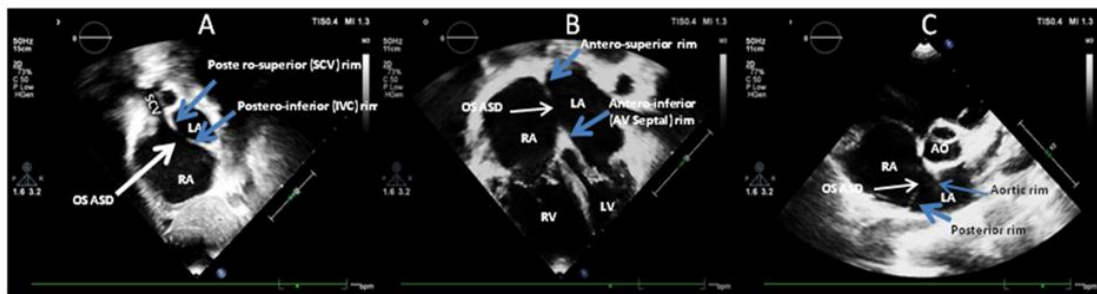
TTE views showing various rims of Os ASD: A – Modified sagittal subcostal view; B Apical 4-chamber view; C- Parasternal short axis view; RA = Right atrium; LA = Left atrium; RV = Right ventricle; LV = Left ventricle; SCV = Superior caval vein; Ao = Aorta
